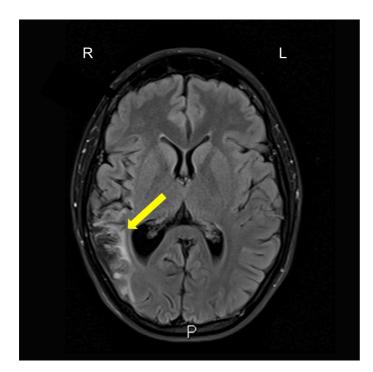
Axial MRI slice from the fluid-attenuated inversion recovery (FLAIR) image, demonstrating a single infarct in the territory of the inferior division of the right middle cerebral artery. The FLAIR image shows differences in the transverse relaxation time of tissues, with a long inversion time to remove signal from the cerebrospinal fluid. The yellow arrow indicates the damaged area, as shown by abnormal brightness (higher signal) in the right hemisphere (compare left and right sides of the image). We observed damage affecting cortical and subcortical regions of the inferior parietal lobule, the parietal operculum, the posterior aspect of the superior temporal gyrus, part of the postcentral gyrus, and the temporo-parietal junction into planum temporale and Heschl's gyrus. R: Right; L: Left; P: Posterior.
